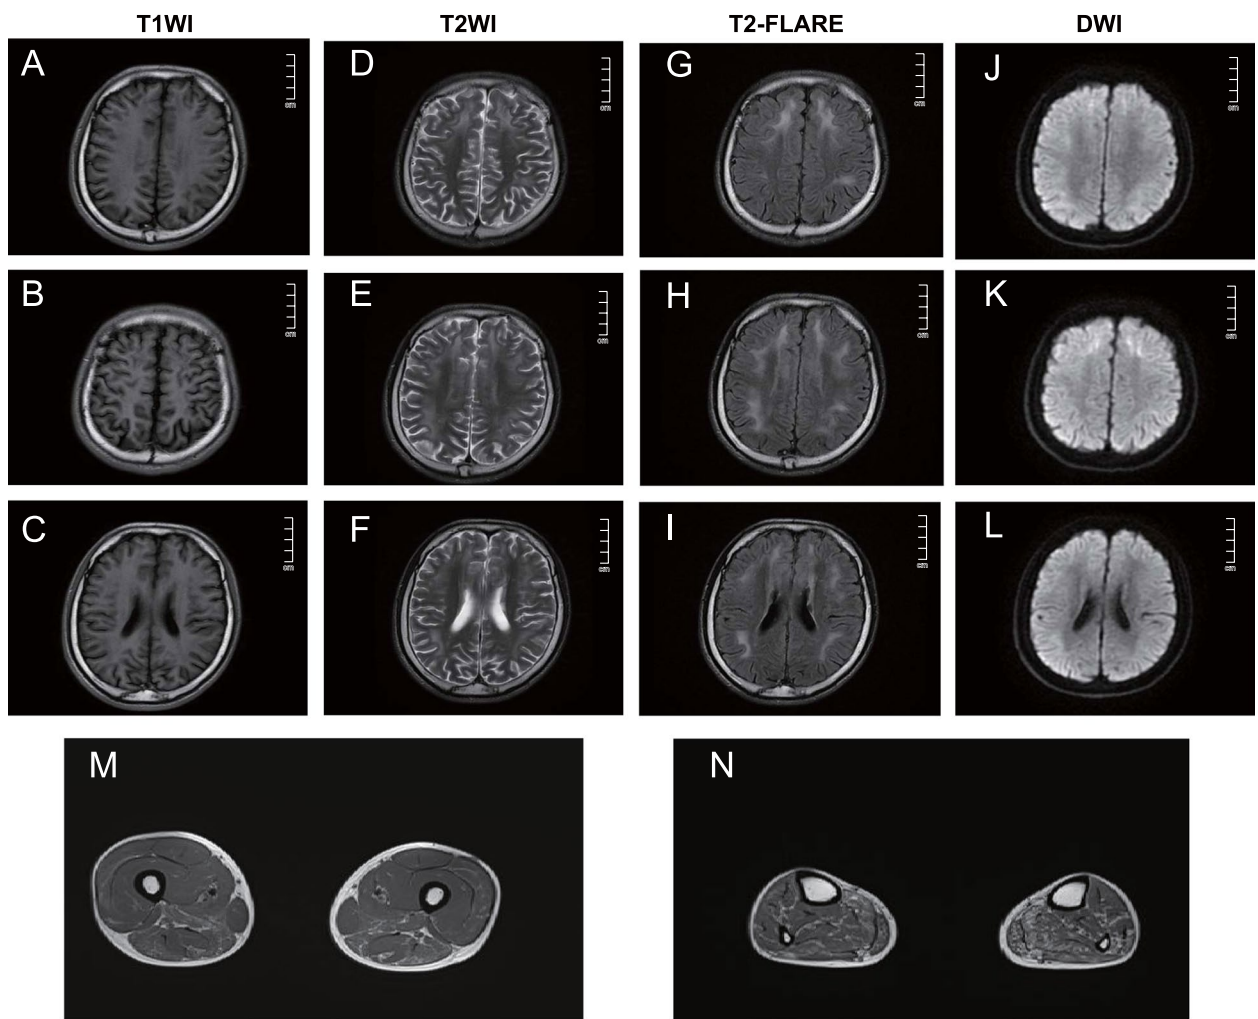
Brain (A-L) and muscle MRI (M, N) findings. Brain MRI revealed bilateral subcortical high-intensity lesions in the centrum semiovale and anterior and posterior horns of the lateral ventricle on T2WI (D, E, F) and FLAIR (G, H, I) images. The corresponding lesions were characterized by high signal intensity on DWI sequences (J, K, L). Muscle MRI showed fatty infiltration and the atrophy of the lower limb muscles. The distal muscles (N calf level) were more severely affected than the proximal muscles (M thigh level), and the posterior muscles were more severely affected than the anterior muscles
